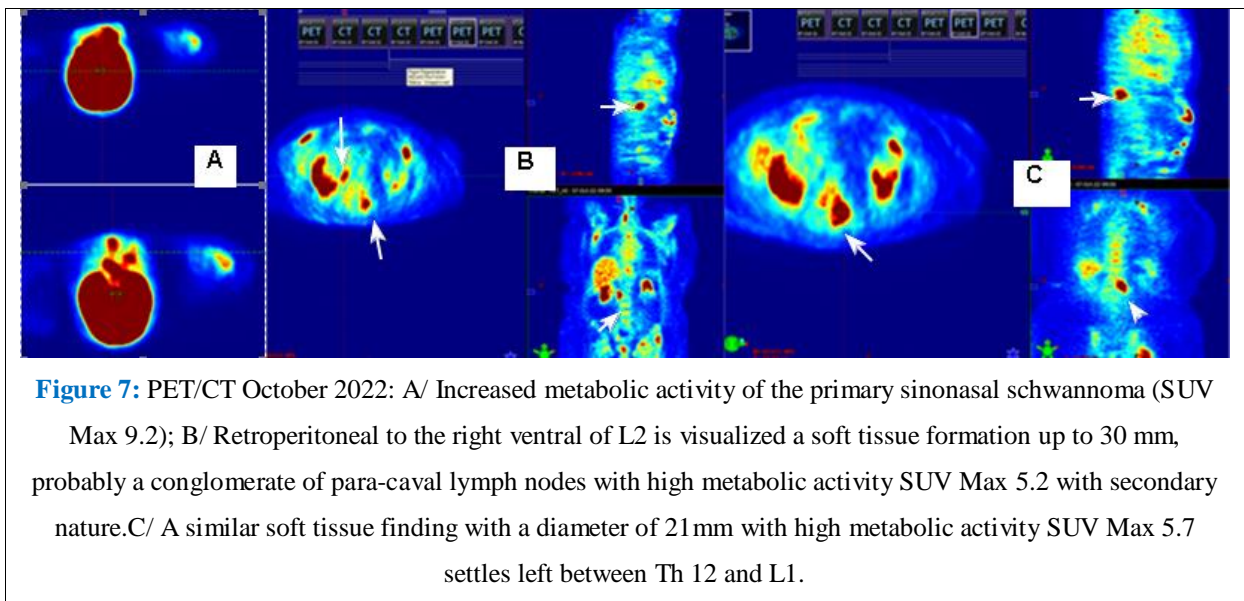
PET/CT October 2022: A/ Increased metabolic activity of the primary sinonasal schwannoma (SUV Max 9.2); B/ Retroperitoneal to the right ventral of L2 is visualized a soft tissue formation up to 30 mm, probably a conglomerate of para-caval lymph nodes with high metabolic activity SUV Max 5.2 with secondary nature. C/ A similar soft tissue finding with a diameter of 21 mm with high metabolic activity SUV Max 5.7 settles left between Th 12 and L1.
